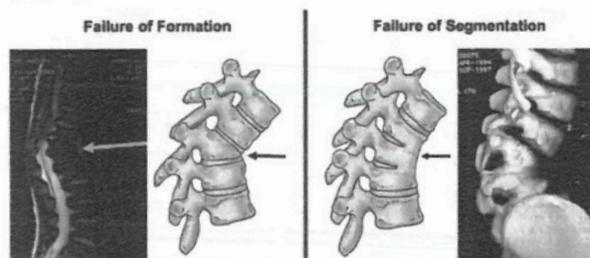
MRI showing multiple wedged vertebrae (left image), failure of segmentation (right image). CT 3D reconstruction shows an example of combined vertebrae (right) [20].
